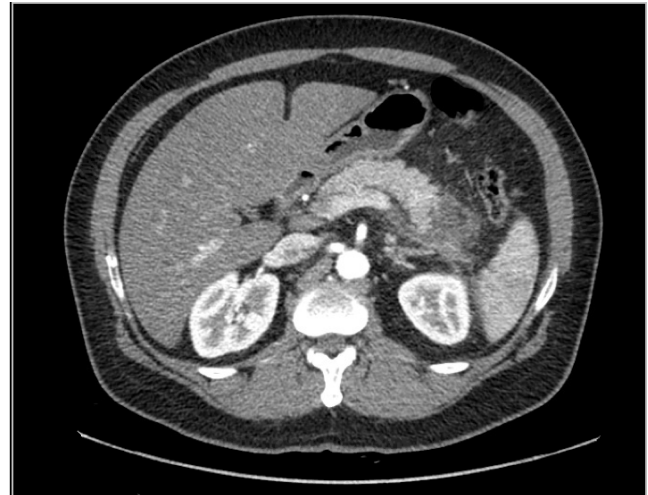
CT Abdomen with IV Contrast
